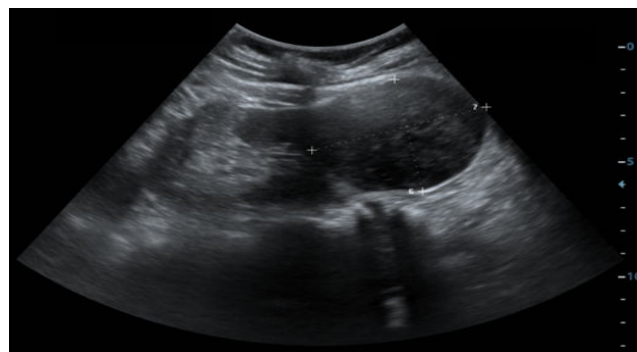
Ultrasound of abdomen showing a heterogenous lesion arising from the lower pole of left kidney.
